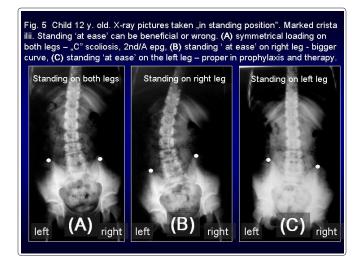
Child 12 y. old. X-ray pictures taken ,,in standing position". Marked crista ilii. Standing 'at ease' can be beneficial or wrong. (A) symmetrical loading on both legs - ,,C" scoliosis, 2nd/A epg, (B) standing 'at ease' on right leg - bigger curve, (C) standing 'at ease' on the left leg - proper in prophylaxis and therapy
